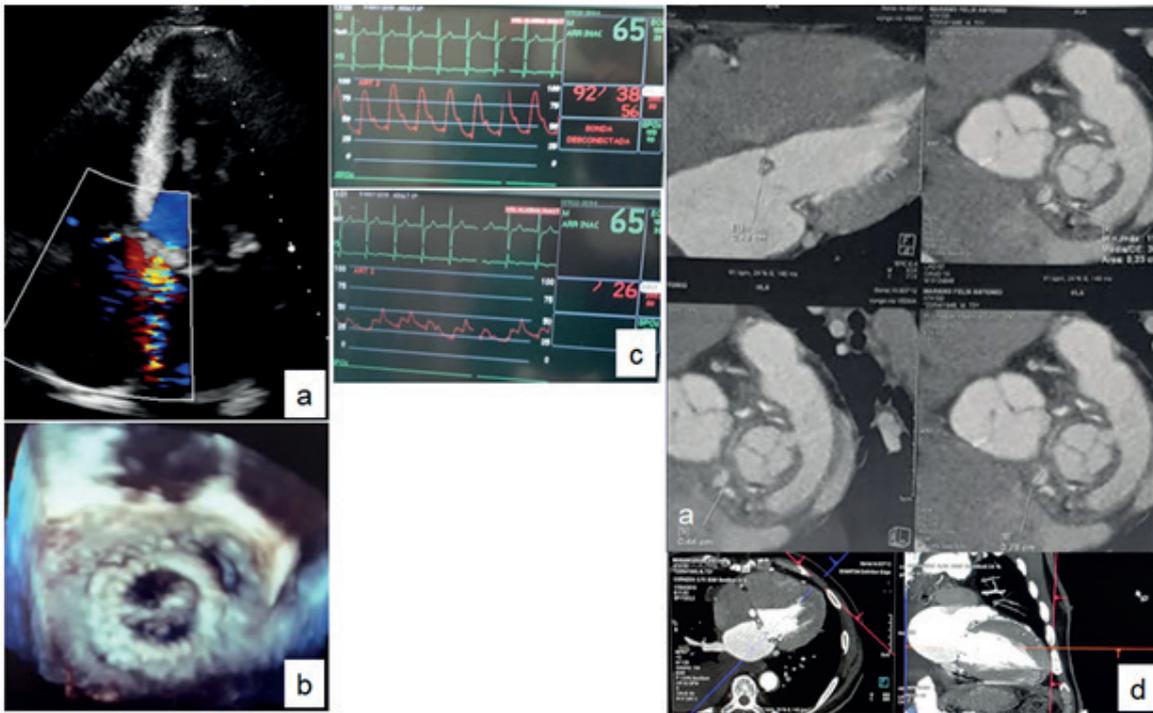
Assessment prior to the closure of the leak via transapical access. a) Echo-Doppler study: Paraseptal mitral regurgitation jet. b) 3D TEE "en face": leak of 12 mm maximum diameter in hour 2. c) Hemodynamic repercussion: PAP, 92/38 (56) mmHg; PCWP, 26 mmHg; V wave, 54 mmHg. d) Volume CT scan: assessment of the leak and transapical access.
